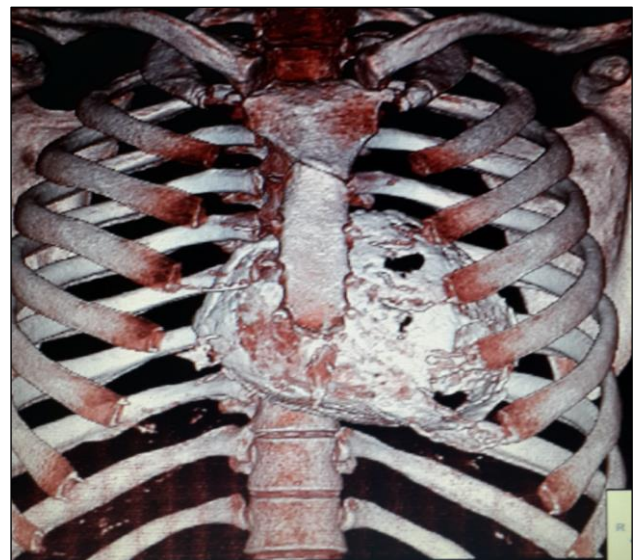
Non-contrast CT reconstructed volume rendered image shows pericardial “Egg-Shell” calcification around the heart.
